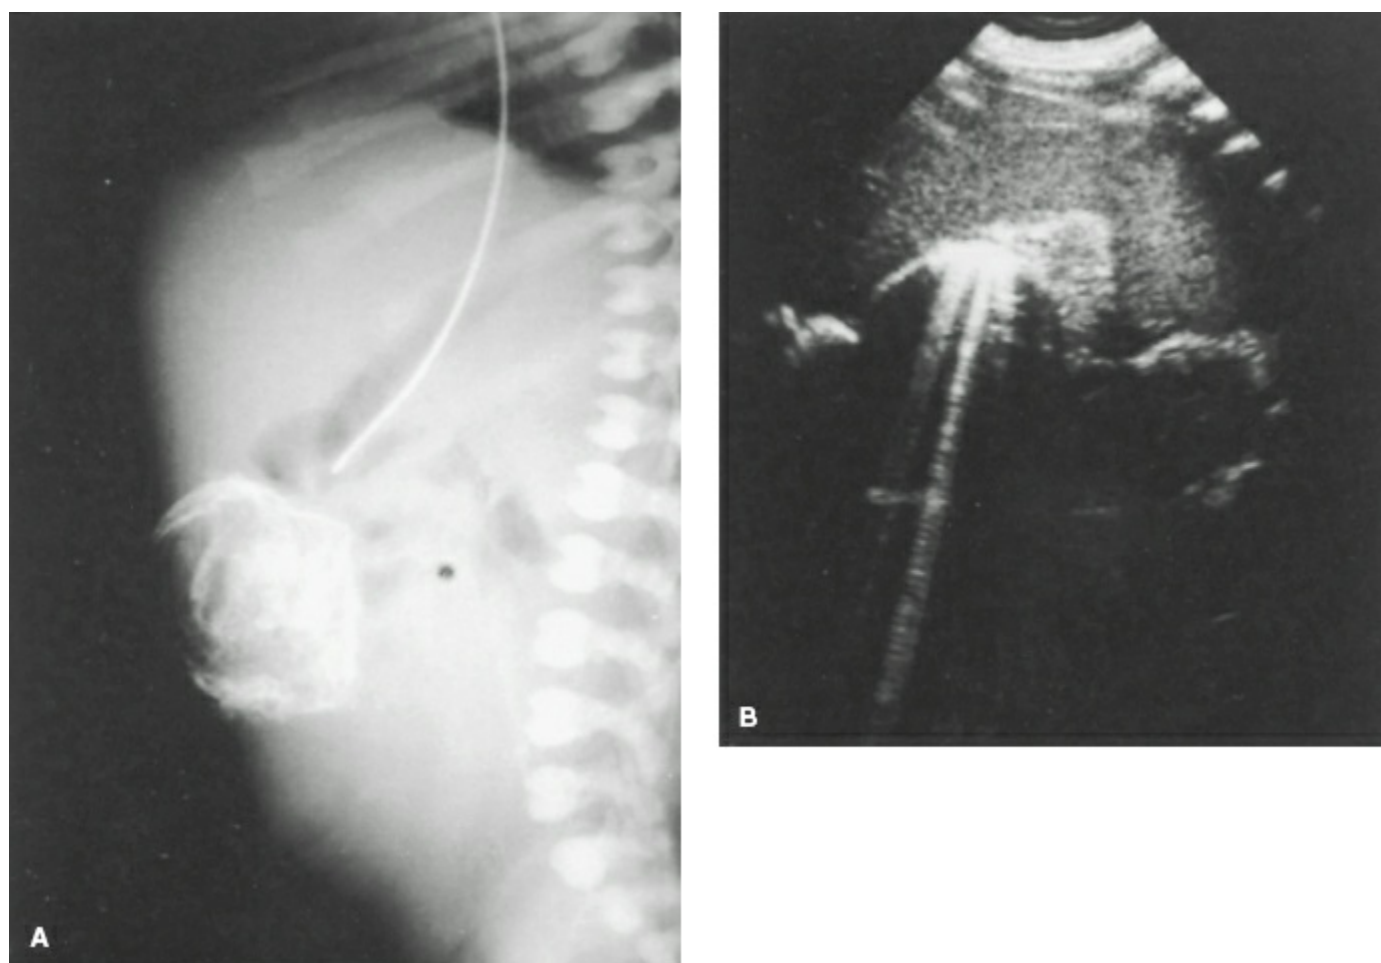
A: Plain film radiograph of calcified pseudocyst in complicated meconium ileus. B: In utero ultrasound demonstrating calcified pseudocyst.
